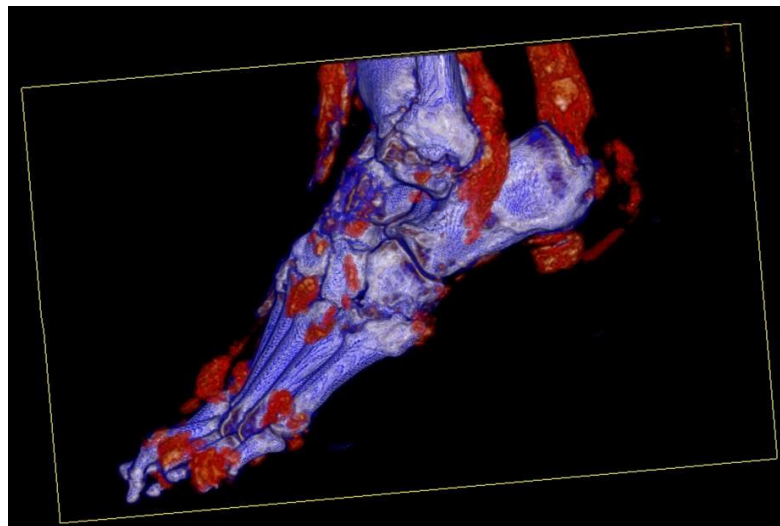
Dual energy computed tomography scan.
